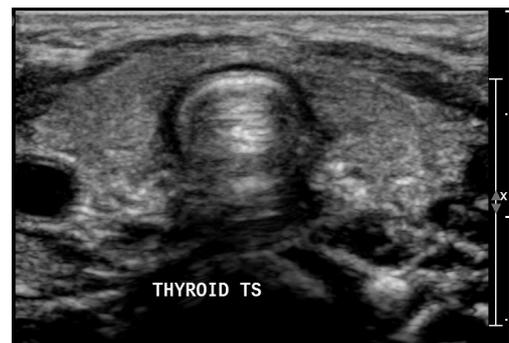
Ultrasound of thyroid gland.
